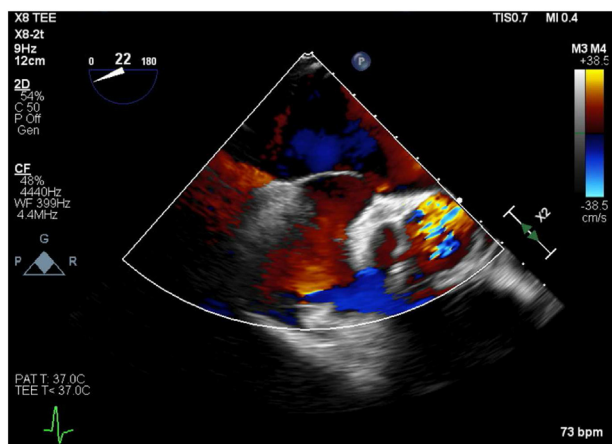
Transesophageal echocardiography with doppler demonstrating patent foramen ovale with shunting into the left atrium.
